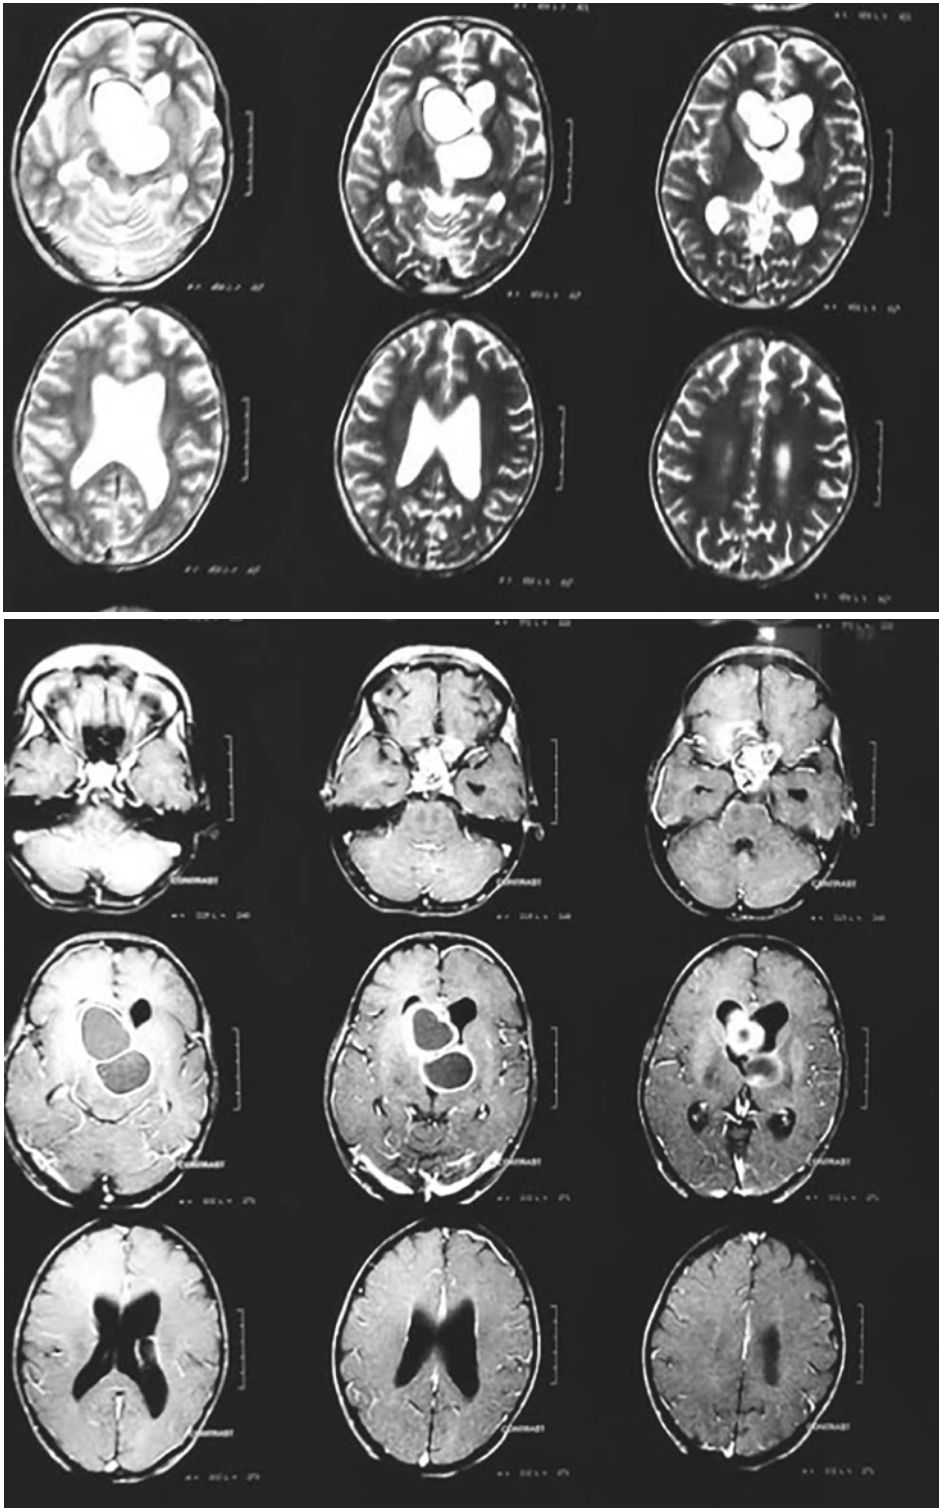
MRI of brain with and without contrast demonstrating well-defined T1 hypointense, T2 flair hyperintense cystic lesion $6 \times 3 \times 2.8$ cm in the suprasellar region extending superiorly into third and fourth ventricles; on
